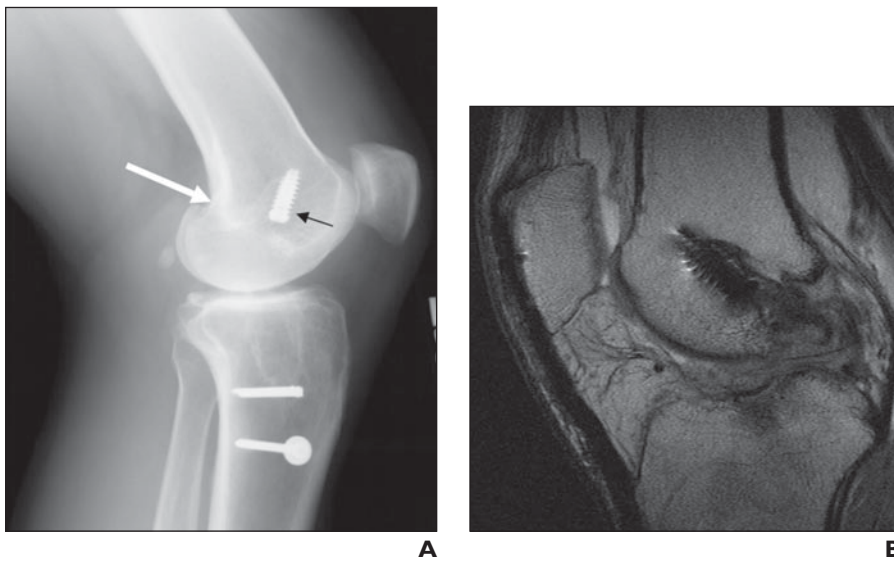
Malpositioned tunnels in 50-year-old man who presented for follow-up imaging after anterior cruciate ligament reconstruction. A, Lateral radiograph shows position of femoral tunnel (*black arrow*) is anterior to intersection of posterior cortex of femur and Blumensaat line (*white arrow*). B, Sagittal T1-weighted MR arthrogram shows femoral tunnel is positioned too far anteriorly and abnormal signal within graft.
